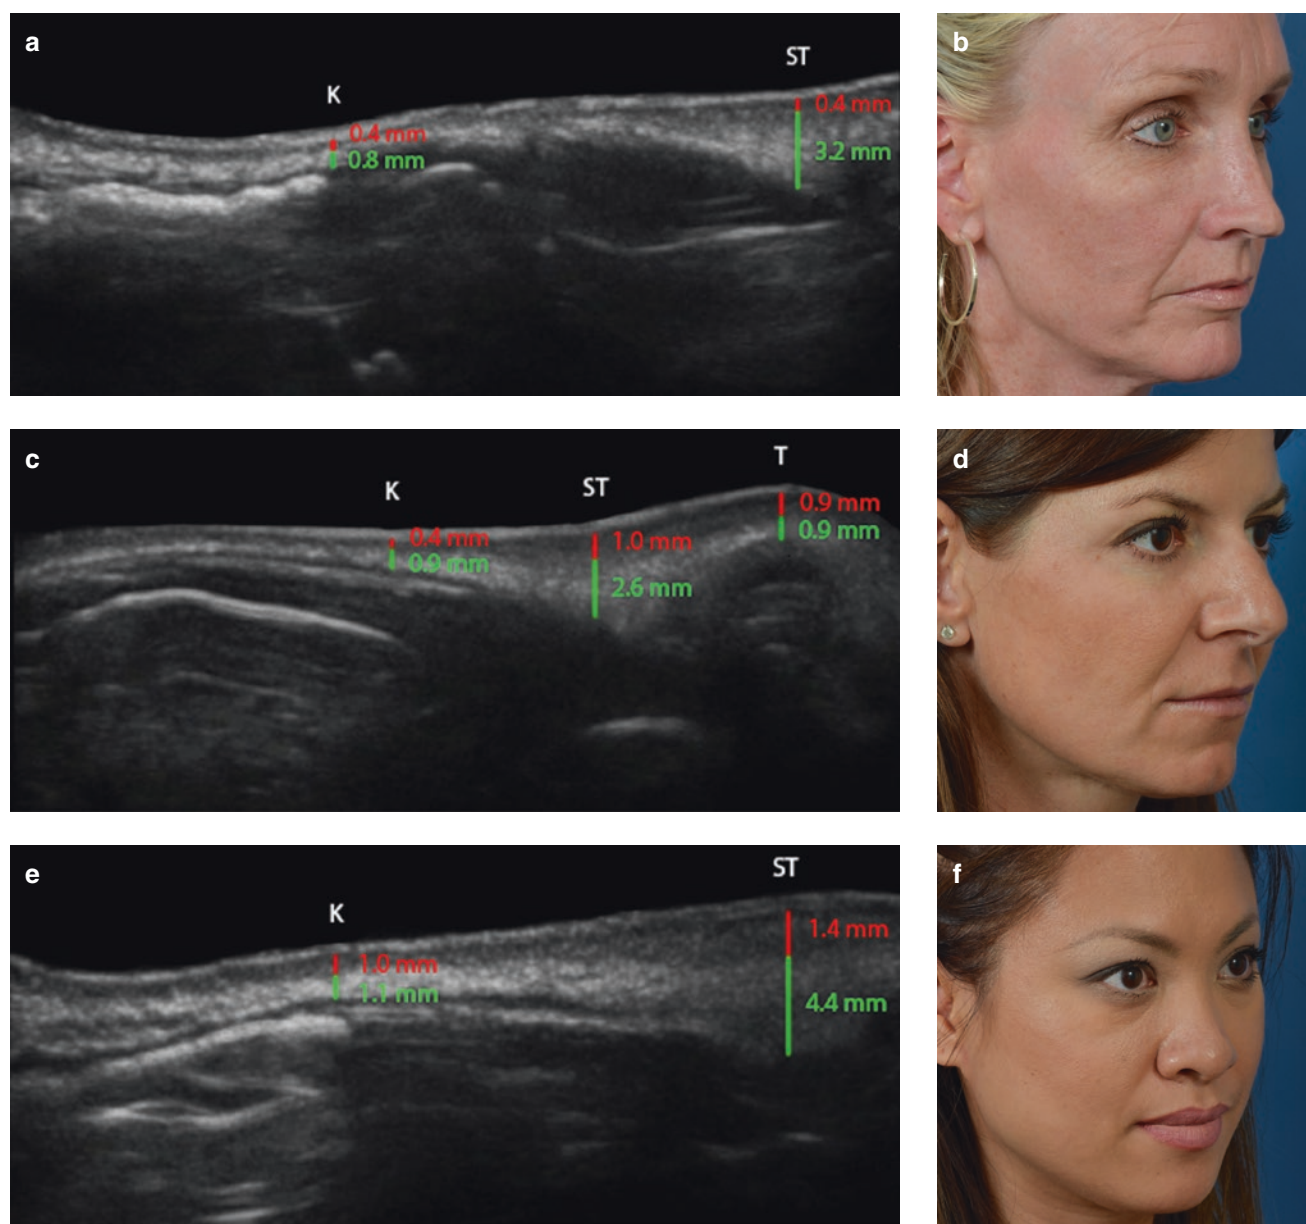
Sonograms of nasal skin, showing the thickness of the dermis (red) and SMAS (green). (a, b) Thin skin. (c, d) Medium skin. (e, f) Thick skin. K keystone junction; ST supratip; T tip (Sonograms courtesy of Aaron Kosins, MD.)
